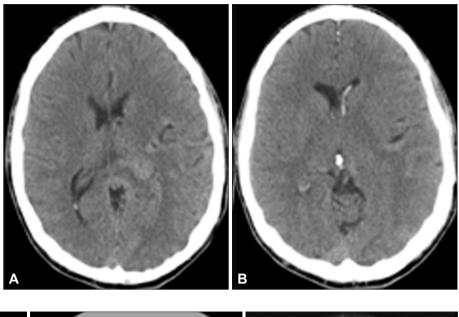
A and B: Axial CT scan without contrast obtained at presentation demonstrates intraventricular hemorrhage within the left frontal horn, right occipital horn, and the third ventricle without evidence of ventriculomegaly.
